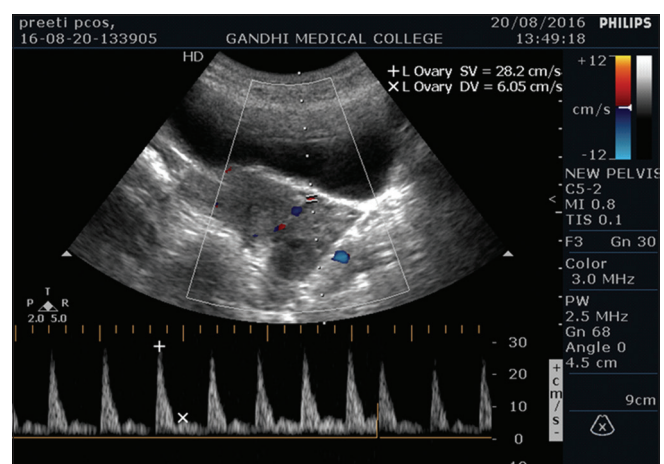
Color Doppler study showing high resistance flow in a control
